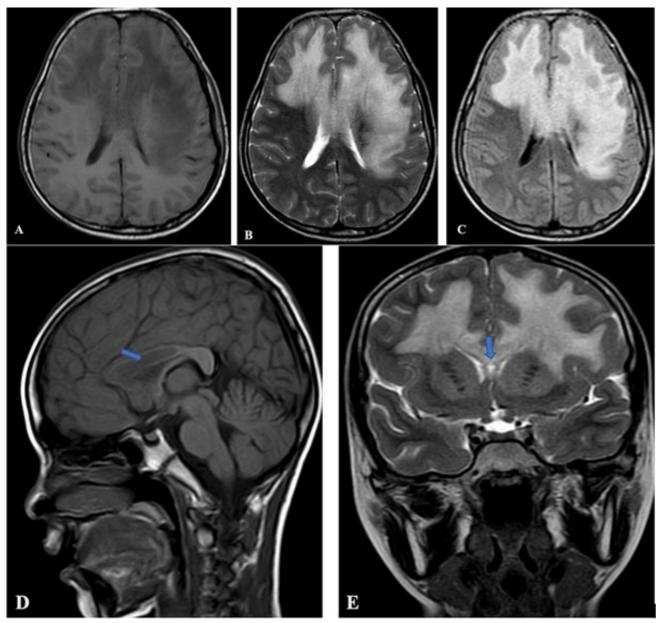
MRI images (A-Axial T1 weighted image, B-Axial T2 weighted image, C-Axial FLAIR image) demonstrating low signal intensity lesion in bilateral cerebral hemisphere, involving white matter of right frontal lobe, left frontal and parietal lobes. The lesion is not suppressed in FLAIR sequence. D-Sagittal T1 weighted image demonstrating involvement of corpus callosum involving rostrum, genu, and body (arrow). E-Coronal T2 weighted image demonstrating T2 high signal intensity lesion involving the white matter of bilateral cerebral hemispheres asymmetrically with involvement of corpus callosum (arrow).
